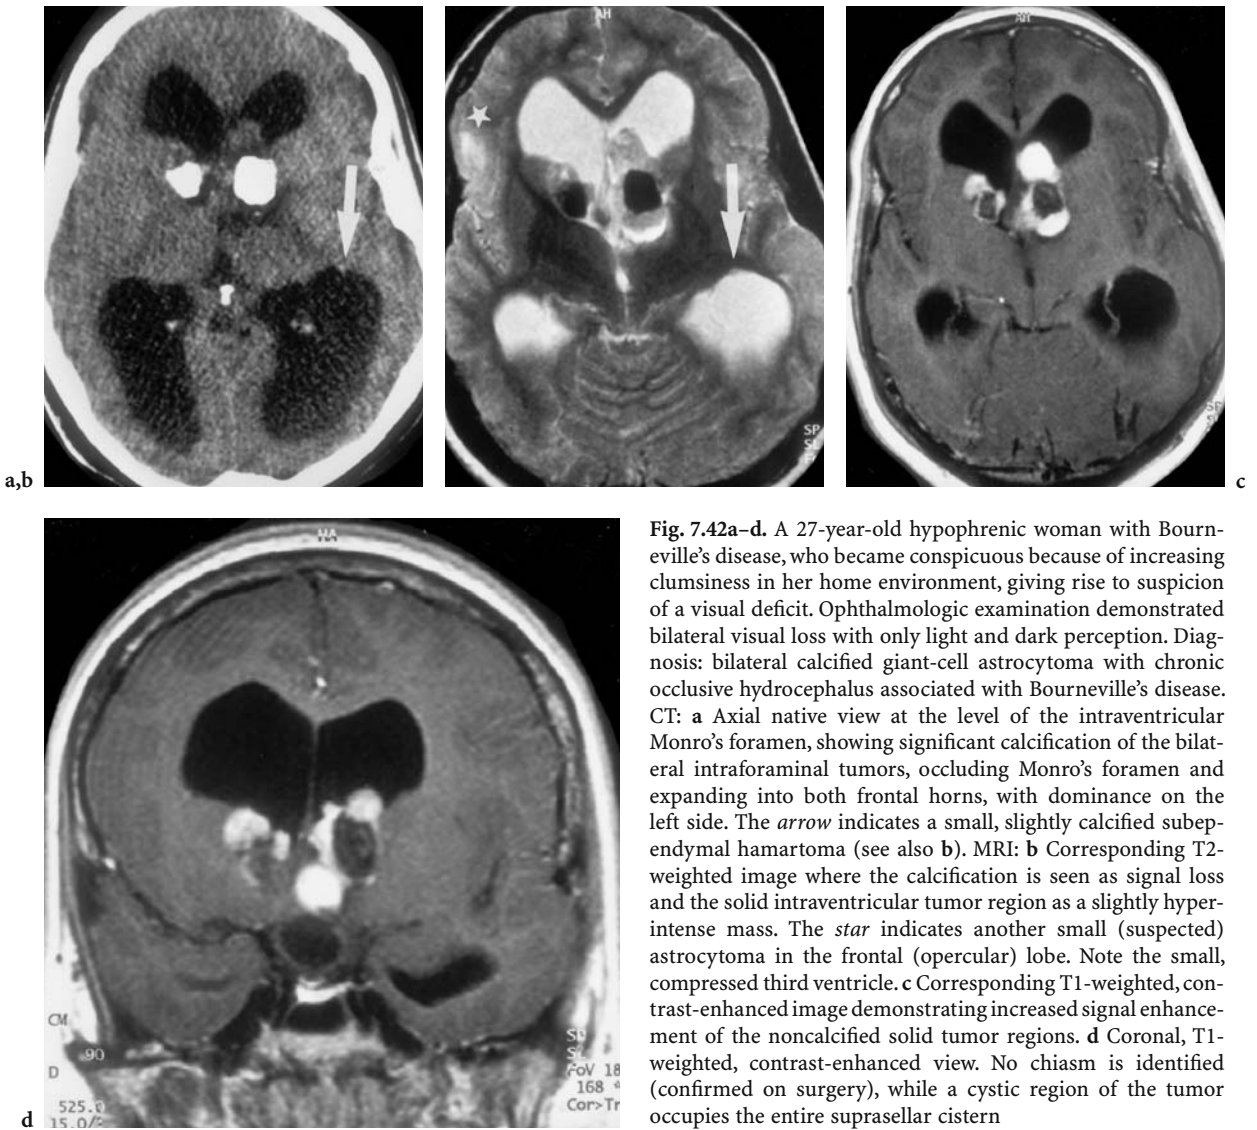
A 27-year-old hypophrenic woman with Bourneville’s disease, who became conspicuous because of increasing clumsiness in her home environment, giving rise to suspicion of a visual deficit. Ophthalmologic examination demonstrated bilateral visual loss with only light and dark perception. Diagnosis: bilateral calcified giant-cell astrocytoma with chronic occlusive hydrocephalus associated with Bourneville’s disease. CT: a Axial native view at the level of the intraventricular Monro’s foramen, showing significant calcification of the bilateral intraforaminal tumors, occluding Monro’s foramen and expanding into both frontal horns, with dominance on the left side. The *arrow* indicates a small, slightly calcified subependymal hamartoma (see also b). MRI: b Corresponding T2-weighted image where the calcification is seen as signal loss and the solid intraventricular tumor region as a slightly hyperintense mass. The *star* indicates another small (suspected) astrocytoma in the frontal (opercular) lobe. Note the small, compressed third ventricle. c Corresponding T1-weighted, contrast-enhanced image demonstrating increased signal enhancement of the noncalcified solid tumor regions. d Coronal, T1-weighted, contrast-enhanced view. No chiasm is identified (confirmed on surgery), while a cystic region of the tumor occupies the entire suprasellar cistern
